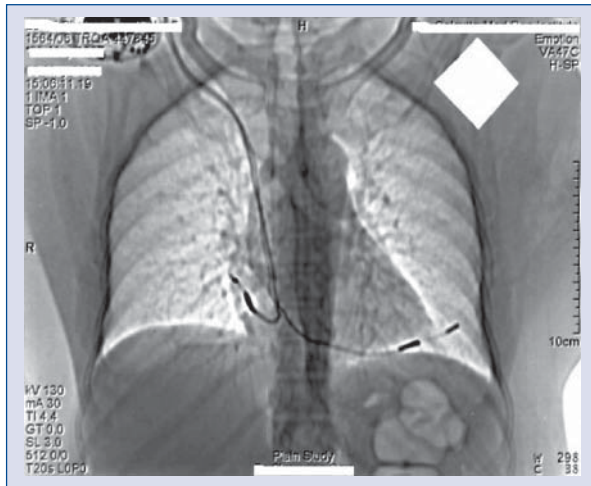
Computed tomography scan showing perforated ventricular lead outside cardiac shadow.
